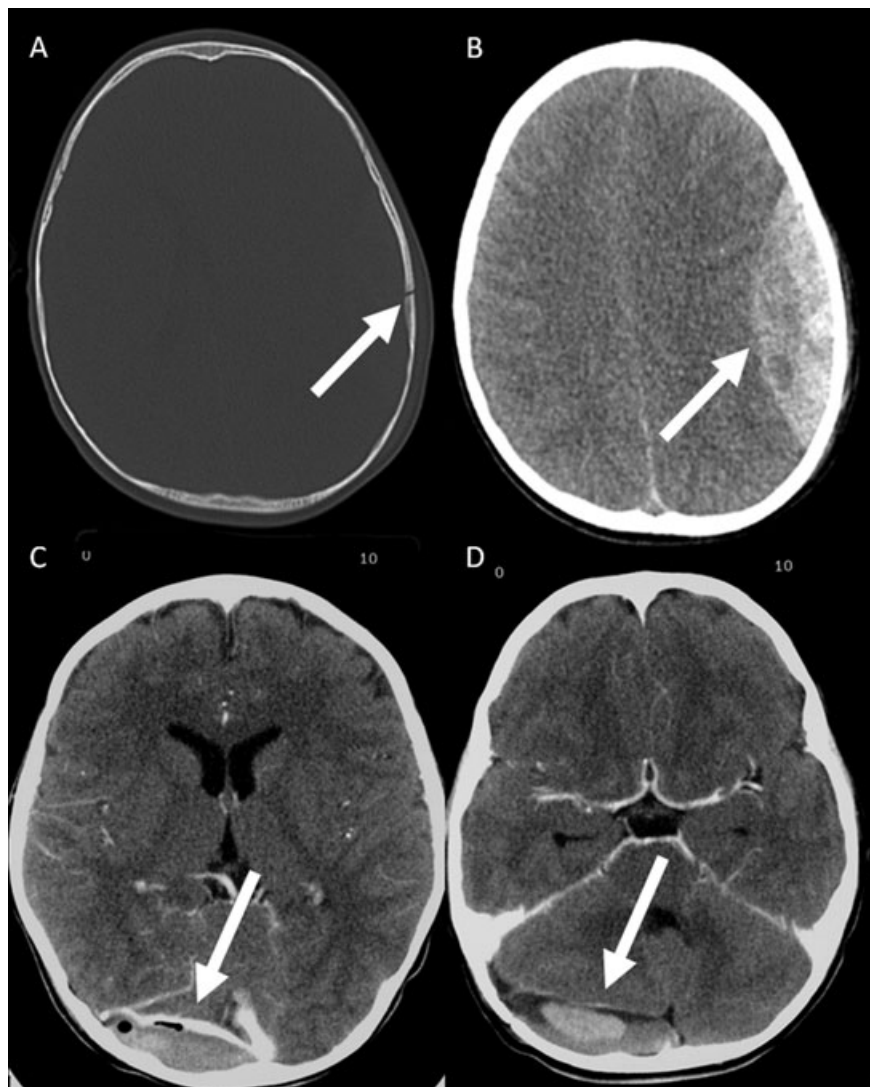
Axial CT images (A, B) of a 2-year-old boy who fell from 6 feet reveal a nondisplaced left temporal fracture with an underlying crescent shaped, hyperdense epidural hematoma (arrow). The extension of the EDH is limited by the coronal and lambdoid suture. Mild mass effect on the adjacent brain with mild midline shift is seen. Axial contrast enhanced CT images in a child with a supratentorial (C) and infratentorial (D) EDH because of a right sided skull base/temporal bone fracture. The EDH elevates and compresses the adjacent transverse sinus (arrow). Small air bubbles are seen within the hematoma which escaped from the fractured mastoid air cells.
